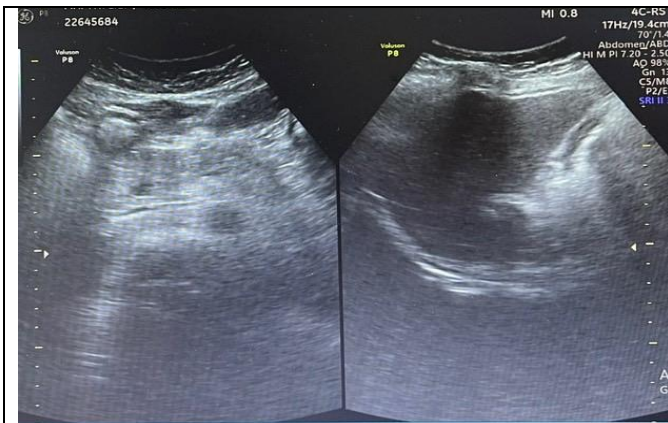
Abdominal ultrasound image
